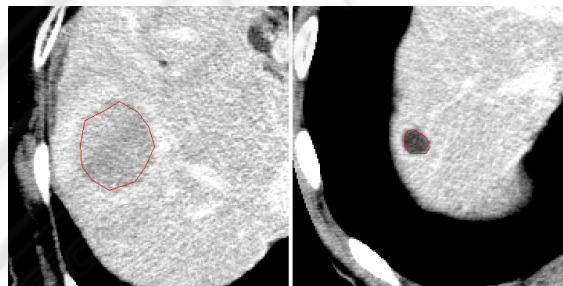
CT images of liver with segmented boundary of hepatic lesions. On the right manually drawn boundary (ROI) of hepatocellular cancer, on the left manually delineated cyst in liver parenchyma.
